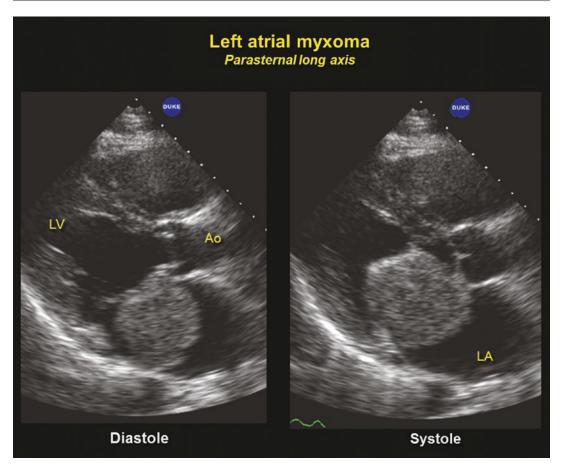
Typical parasternal long axis of a left atrial myxoma, prolapsing into the mitral orifice in diastole
